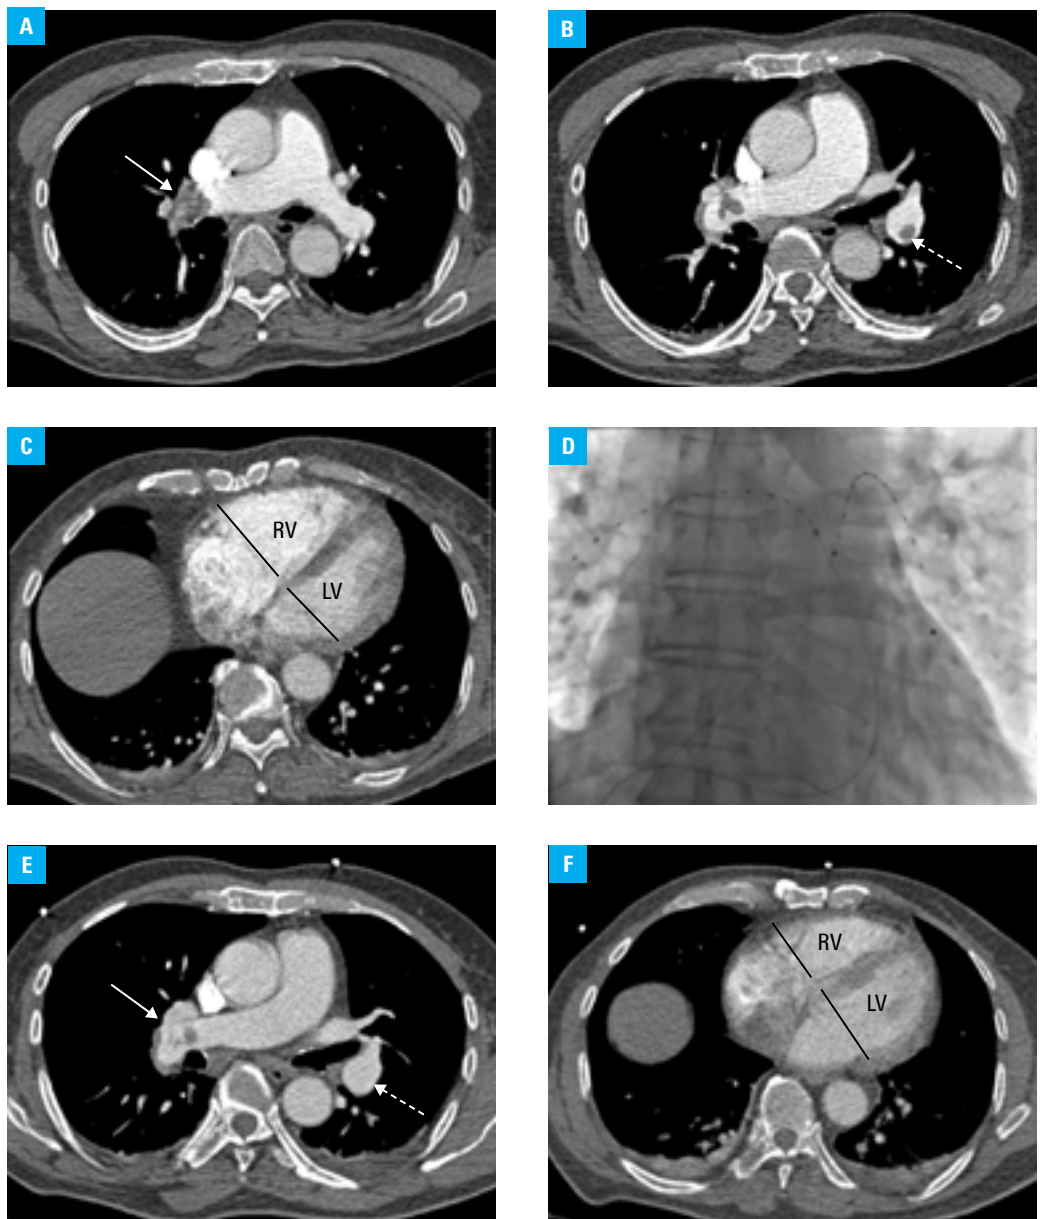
A, B, C – computed tomography pulmonary angiography (CTPA) showing thrombus (arrow) in the proximal right interlobar pulmonary artery (PA) (A) and in the middle part of the left interlobar PA (dashed arrow) (B), causing dilation of the right ventricle with the right ventricular-to-left ventricular (RV/LV) ratio of 1.2 (C); D – fluoroscopy showing two EkoSonic® MACH4 catheters of the EKOS™ system (Ekos Corp., Bothel, Washington, United States) for ultrasound-assisted, catheter-directed, low-dose thrombolysis (USAT), located in the right and left PAs beyond the thrombi; E, F – CTPA performed after 5-hour USAT with the total alteplase dose of 10 mg, showing thrombus resolution in the left PA (dashed arrow) and a reduction of thrombus burden in the right PA (arrow) (E), leading to a decrease in the RV/LV ratio to 0.86 (F). Moreover, the USAT led to a gradual relief of dyspnea, an increase of systolic blood pressure to 110 mm Hg and oxygen saturation to 95%, a decrease of heart rate to 90 bpm, and a decrease of the N-terminal-pro-B-type natriuretic peptide level from 4784 pg/ml to 3321 pg/ml and of the troponin T level from 0.115 ng/ml to 0.098 ng/ml.
